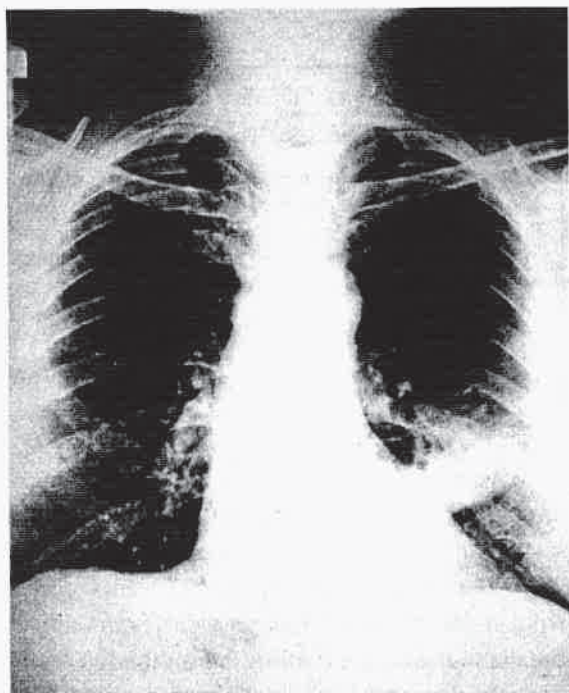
Chest X-ray showing an ill-defined mass in the left lower zone
